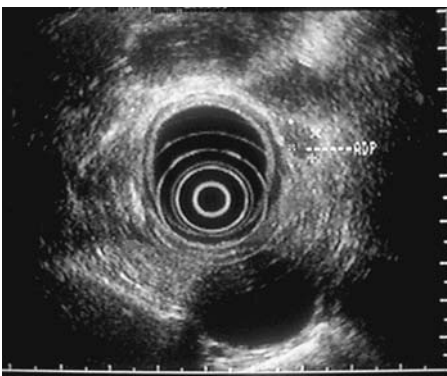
Endosonography reveals numerous hypoechoic nodes surrounding the esophagus, (Courtesy of Eric François, M.D., Centre Antoine-Lacassagne, Nice, France.)
